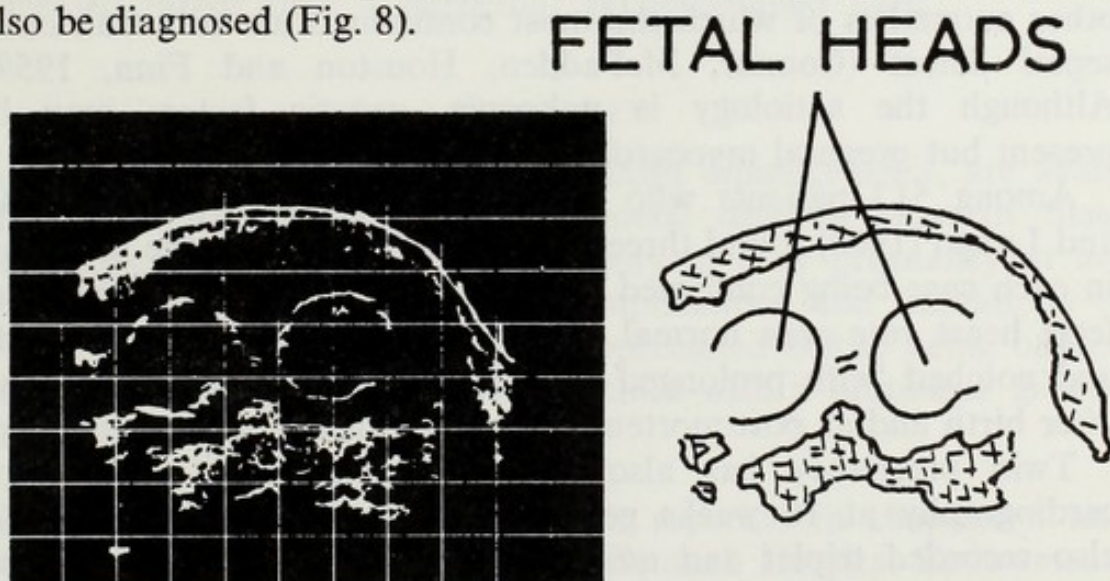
Transverse ultrasound scan: twin pregnancy.
